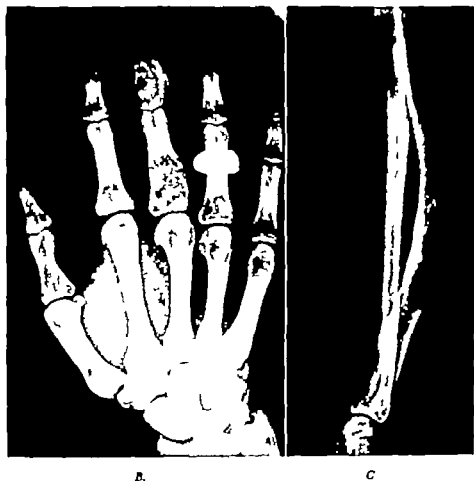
(cont'd) —B Roentgenogram from a case of enchondromatosis limited to the proximal and middle phalanges of the third finger of a hand. C Another instance of limited Ollier's disease in obliq the radius, which is bowed (as well as some of the bones of the corresponding hand)
